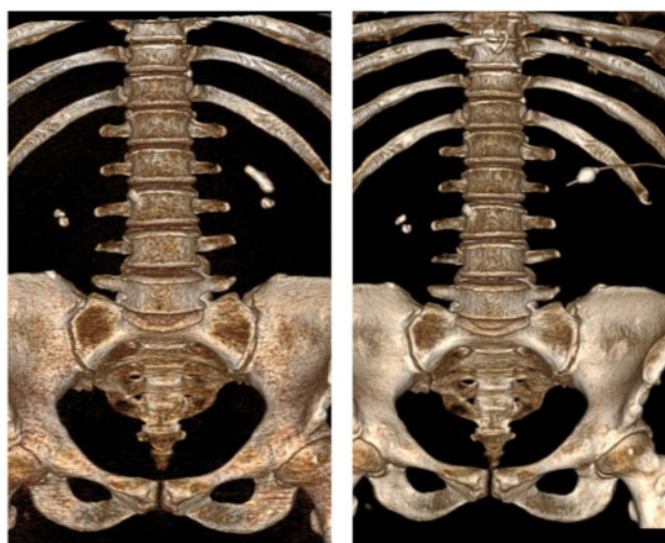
3D Volume rendering computed tomography (VR CT) scan before and after mini-percutaneous nephrolithotomy (PCNL).
